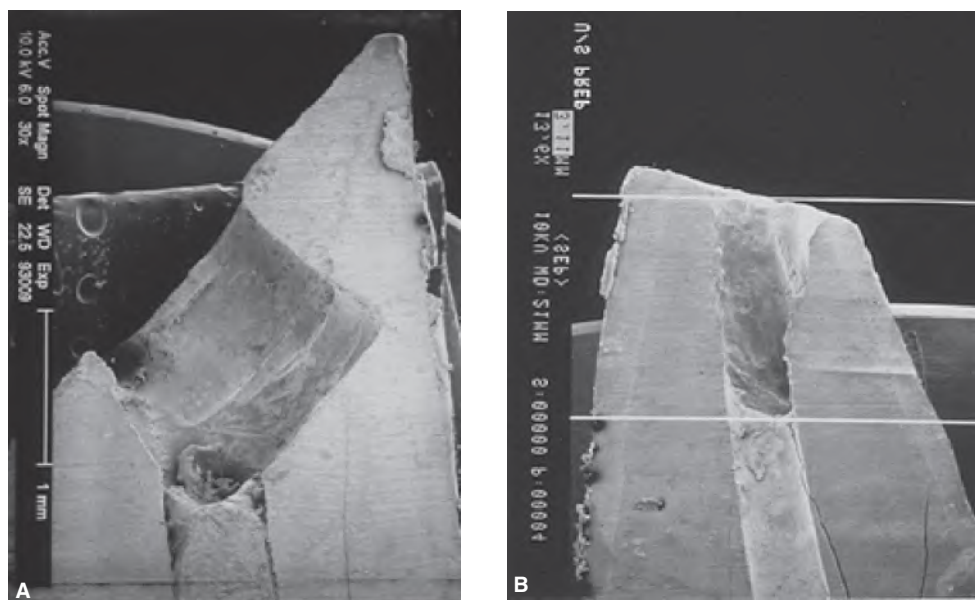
A. SEM image of a root-end cavity prepared by a small inverted bur. B. SEM image of a root-end cavity preparation by an ultrasonic bur.
